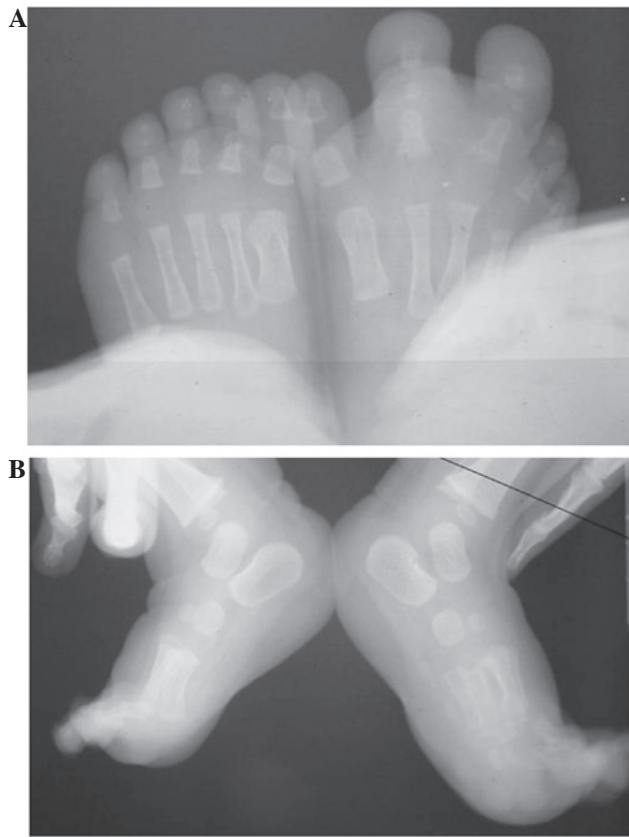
(A) Anterior-posterior and (B) lateral radiographic images revealing macrodactyly of the second and third digits with disproportionately increased length and width of the phalanges and metatarses accompanied by an increase in the surrounding soft-tissue density.
